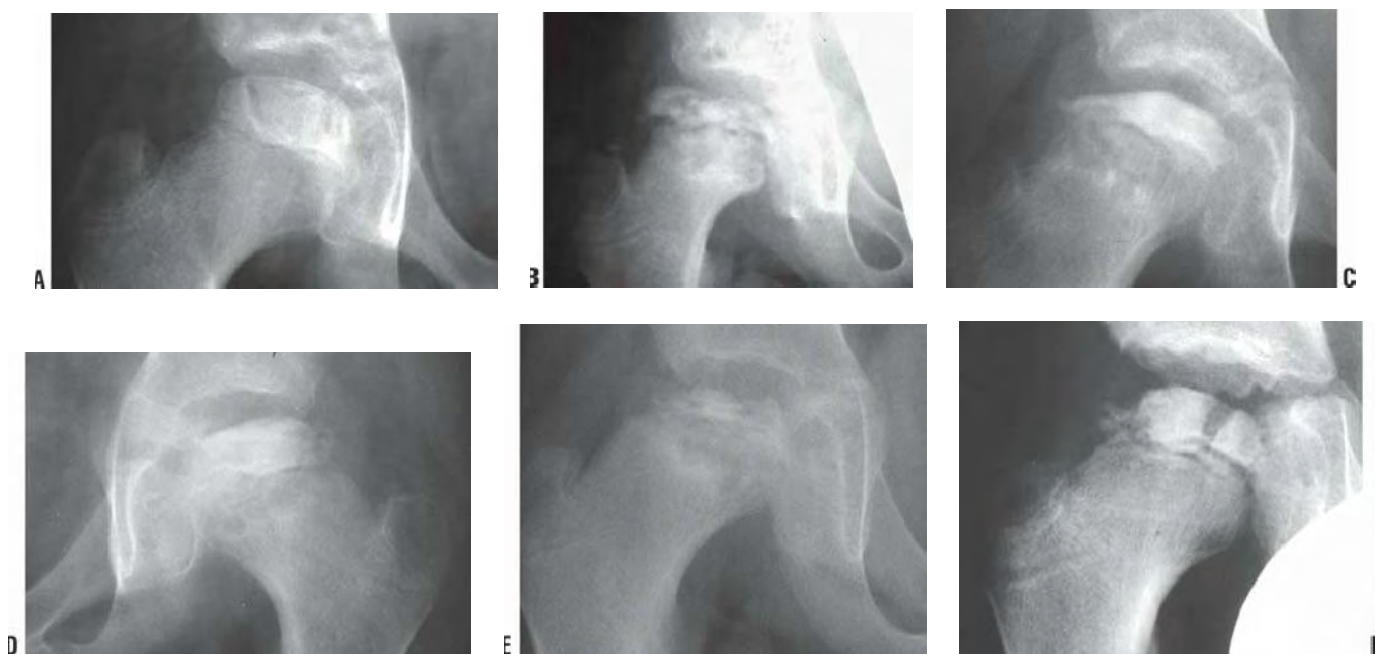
The lateral pillar classification. A: Lateral pillar A; B: Lateral pillar B; C: Lateral pillar C; D–F: B/C Border examples. (Reprinted from Herring JA, Kim HT, Browne R. Legg-Calvé-Perthes disease: part I: classification of radiographs with use of the modified lateral pillar and Stulberg classifications. *J Bone Joint Surg Am.* 2004;86(10):2103–2120, with permission.)
